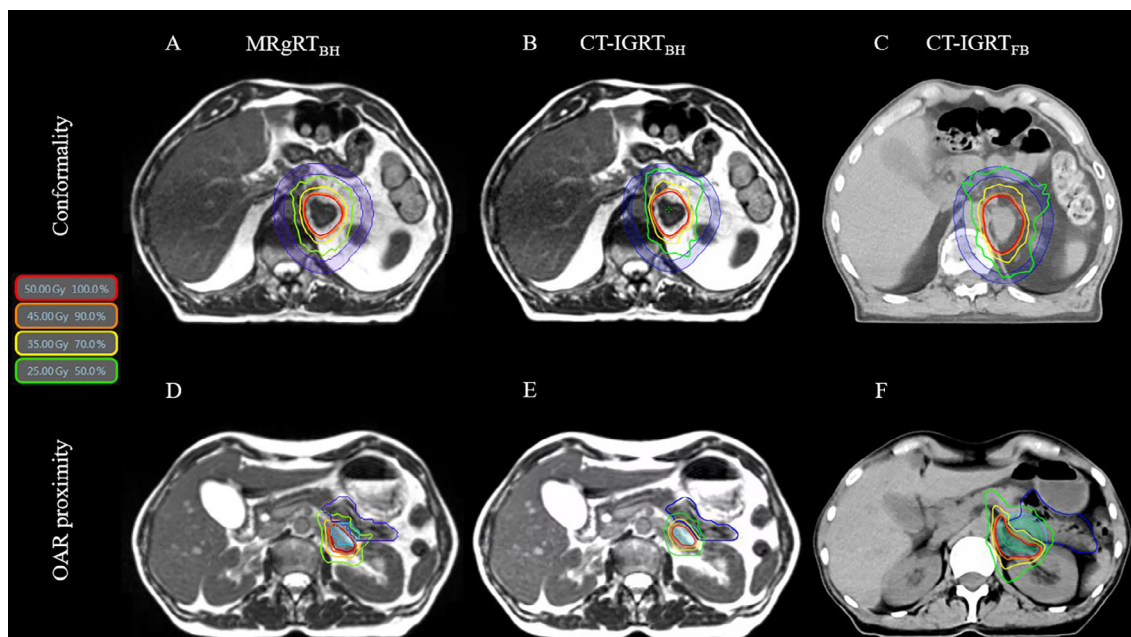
Comparison of plan quality between MRgRT_{BH} (A, D), CT-IGRT_{BH} (B, E), and CT-IGRT_{FB} (C, F) for two cases. The top row demonstrates the loss of low dose conformality in maximum dose to 2 cm (D_{2cm}) from the PTV surface due to the larger target size in free-breathing (C) compared to breath-hold (A, B). The bottom row shows increased overlap of the PTV (cyan) with the proximal small bowel (blue), due to the larger target size in free breathing (F) compared to breath hold (D, E) plans, demonstrating reduced target coverage in the CT-IGRT_{FB} plan. Note: Organ at risk (OAR), MR-guided radiotherapy with breath-hold (MRgRT_{BH}), CT based image-guided radiotherapy with breath-hold (CT-IGRT_{BH}).
